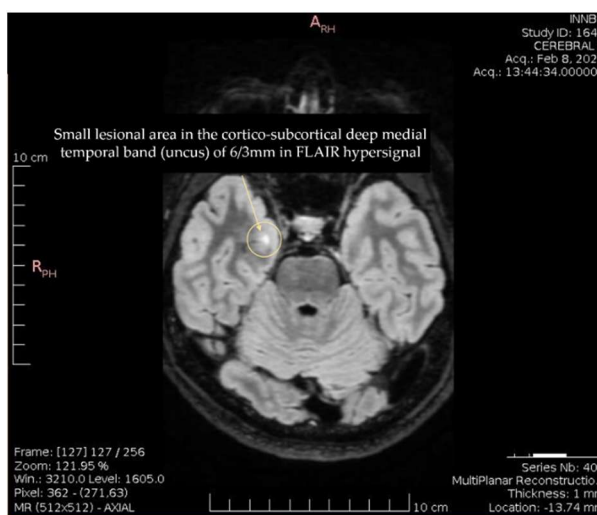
A small lesion measuring 6/3 mm observed in the deep medial temporal cortex at the level of the uncus, hyperintense signal on FLAIR.
